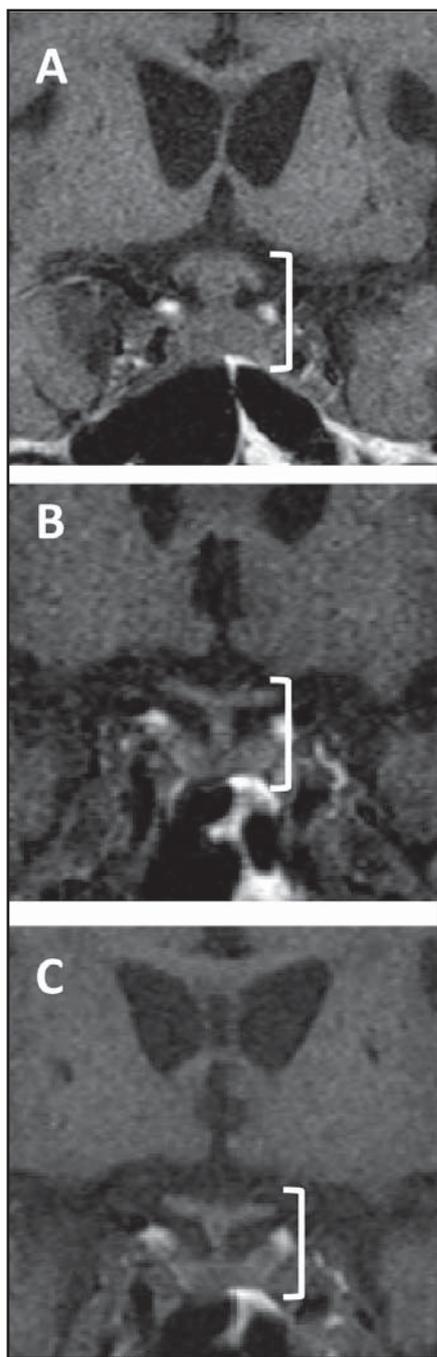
Cranial MRI (T1-weighted images). There was diffuse swelling of the pituitary gland and the hypophyseal stalk (a white bracket) on admission (A). Shrinkage of the pituitary gland and the stalk was observed on Day 39 (B). Shape of the pituitary gland and the stalk was almost normal 4 months after admission (C).
